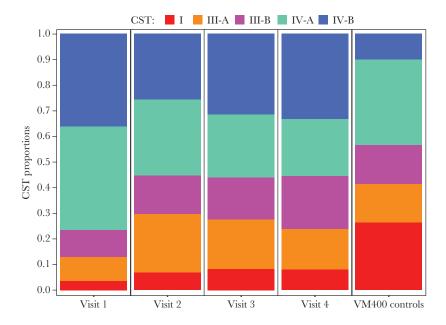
Community state type (CST) proportions in Chlamydia Adolescent/Adult Reproductive Management (CHARM) samples from visit 1 (*Chlamydia trachomatis* [CT] positive, pretreatment), visit 2 (CT negative only, 3 months posttreatment), visit 3 (CT negative only, 6 months posttreatment), and visit 4 (CT negative only, 9 months posttreatment) and in VM400 controls.
